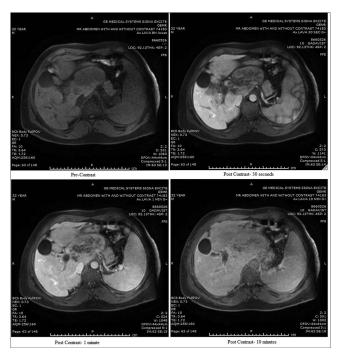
MRI of the abdomen with and without contrast at diagnosis showing a caudate lobe mass enhancing with contrast concerning for cholangiocarcinoma.
